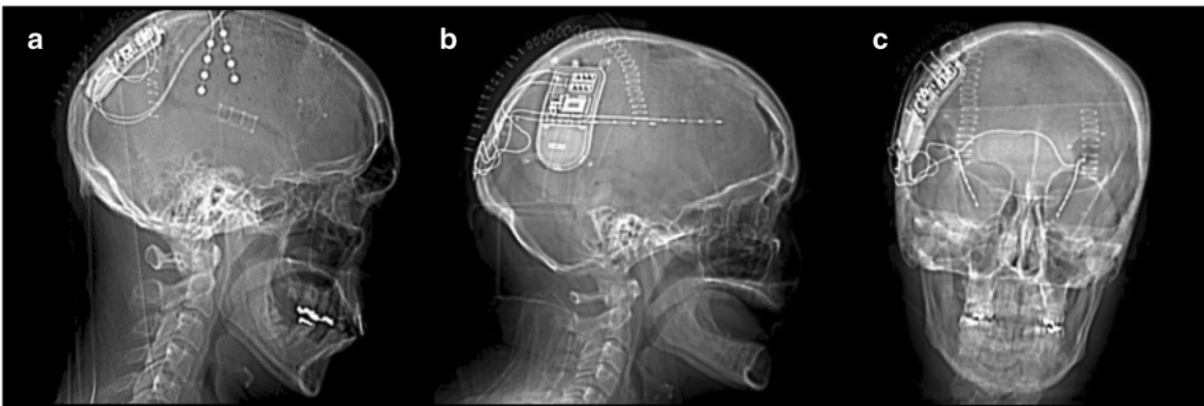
CT scans of three patients after implantation with RNS System [14]
